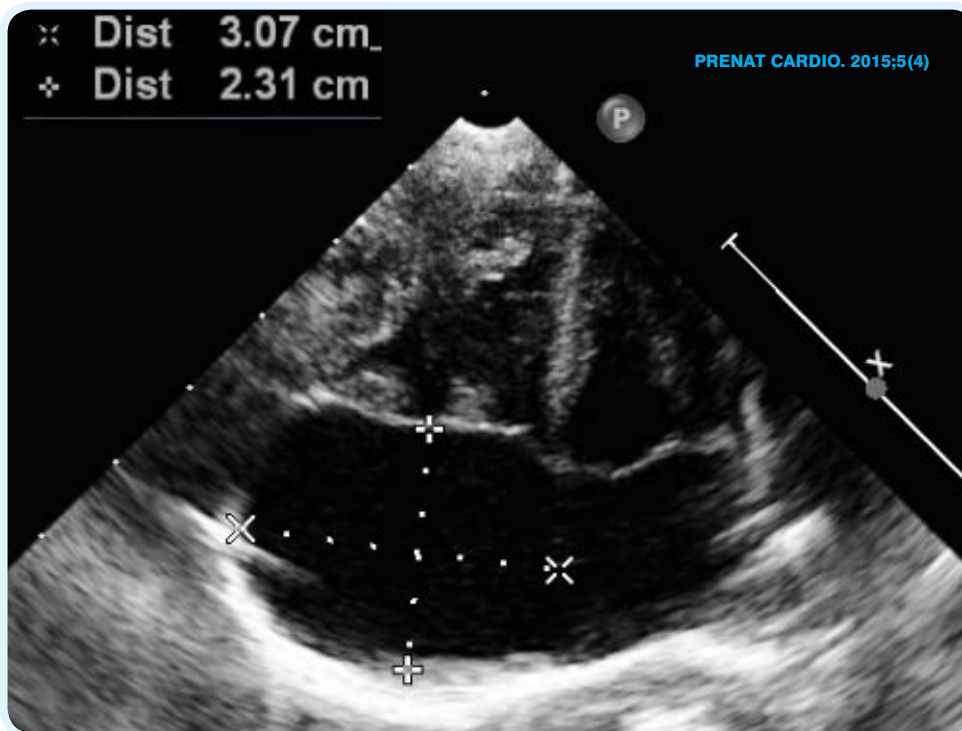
Postnatal echocardiogram in the Department of Pediatric Cardiology
